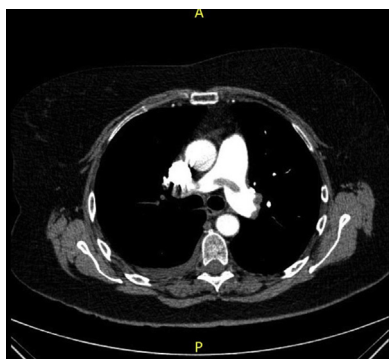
CT Pulmonary angiography shows a saddle pulmonary embolism.
